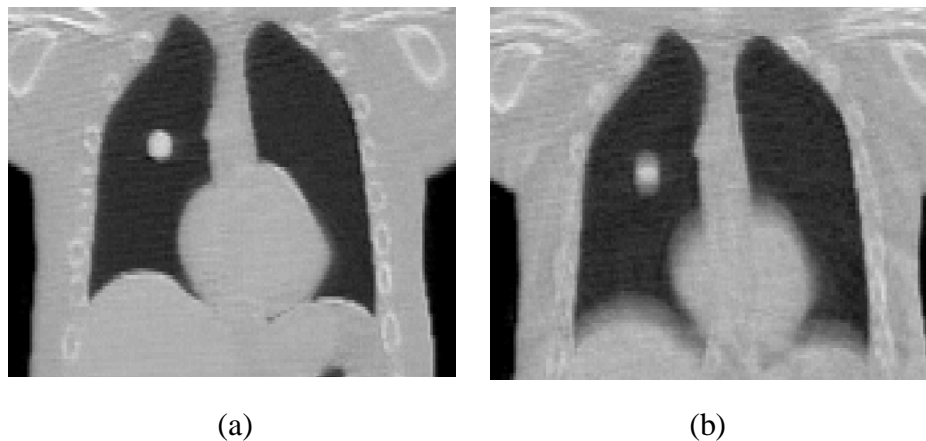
CBCT reconstructed images (a) with no motion, and (b) with respiratory movement.
